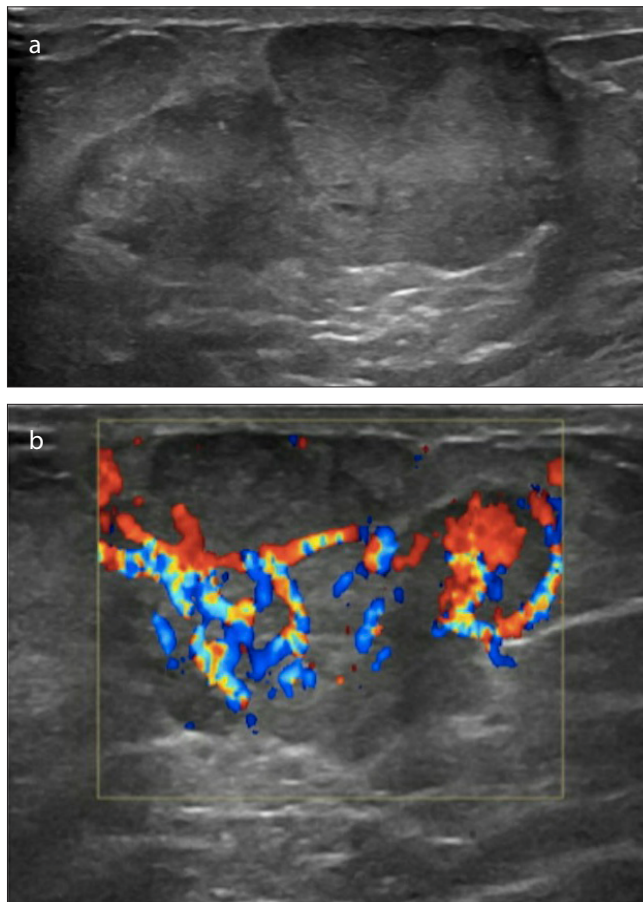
a, b. (a) Ultrasonography, (b) Doppler Ultrasonography. The lesion is round shaped, macrolobulated solid mass with heterogeneous echogenicity. The lesion had an increased internal vascularity
